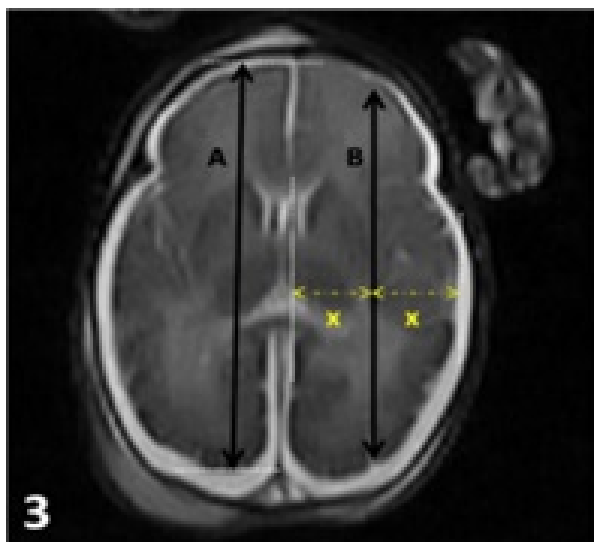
39 weeks of gestational age. axial cranial MR image obtained with T2-weighted sequence in a male fetus A. Right hemispherium cerebri depth. B. Mid-depth of the left hemispherium cerebri.
